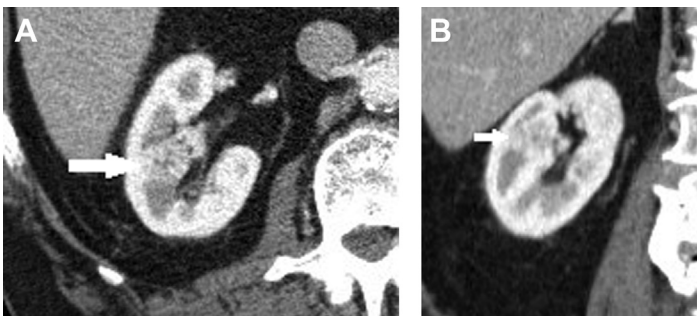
(A) Axial and (B) coronal corticomedullary phase contrast-enhanced CT images of the right kidney show a ccRCC (arrows) that is difficult to detect because its attenuation is similar to that of the surrounding medullary renal parenchyma. One clue to the correct diagnosis is the heterogeneity of enhancement.
